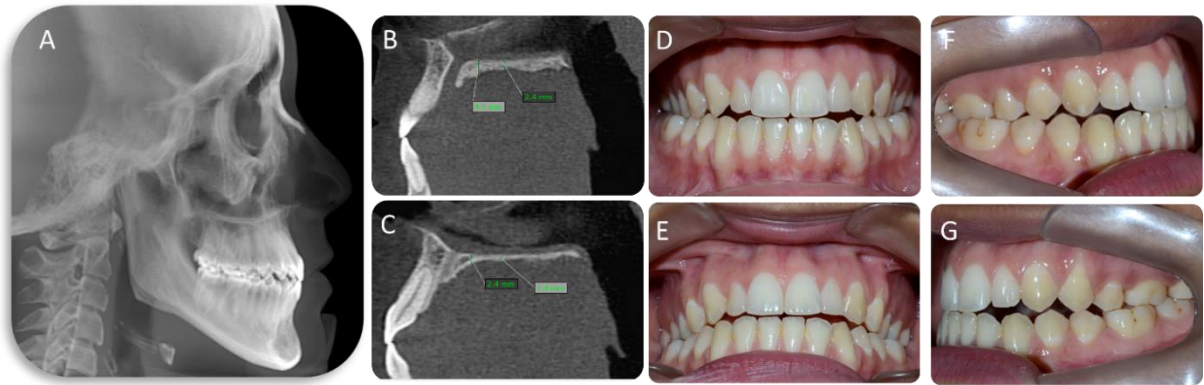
Pre-treatment documentation: A, lateral xray. B, sagittal section of the maxilla from the midpalatal suture region with bone thickness measurements. C, sagittal section of the maxilla from the paramedian region with bone thickness measurements. D,E,F,G patient's intraoral clinical pictures.
